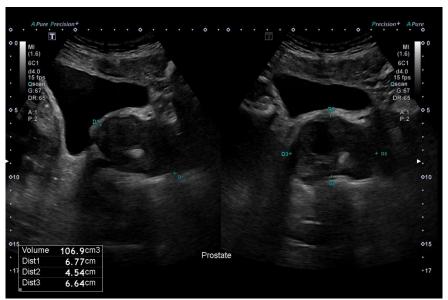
Pre-treatment prostate ultrasound (November 2024)
